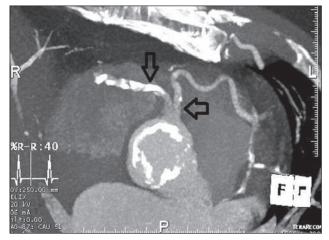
Coronary CT scan showing the separate origins of both the RCA (vertical arrow) and LM (horizontal arrow) from the right sinus of Valsalva.
